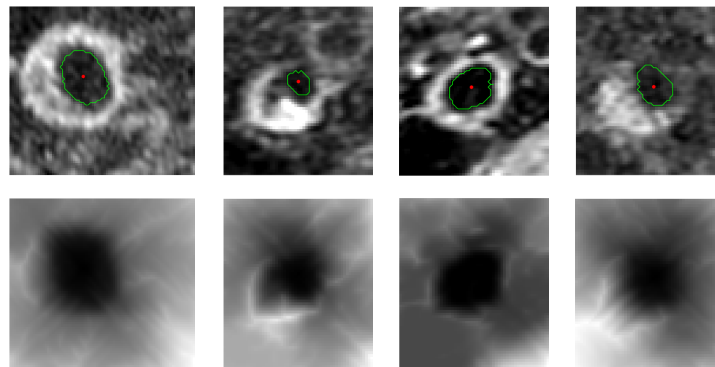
Examples of the gray-weighted distance applied to PDW MR images of carotid arteries: The first row shows the images with the segmented lumen contours represented in green (the starting points of the gray-weighted distance are the red dots that represent the centres of the lumen contours). The second row shows the distance maps calculated by Equation 1.
